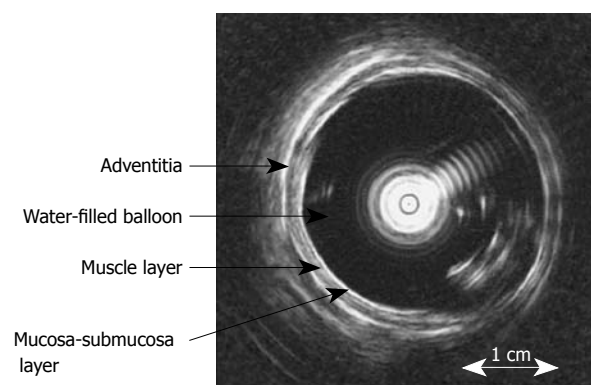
Cross-sectional endosonographic image of the distended distal oesophagus allows identification of three oesophageal sub-layers, i.e. mucosa-submucosa, muscle and adventitia. The white shadows inside the water-filled bag (4-5 o'clock) represent artefacts due to convulsions of the water-filled balloon, which results in reduced image quality at low degrees of distension. Modified from [17].
